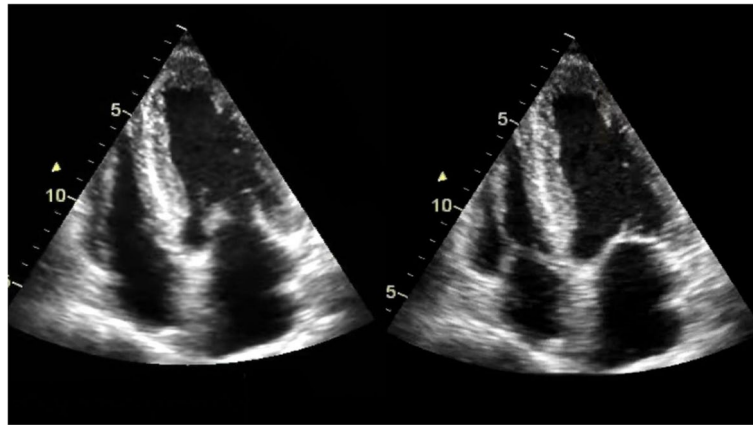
Echocardiogram exhibits symmetric hypertrophy of both the left and right ventricles, accompanied by biatrial dilation
